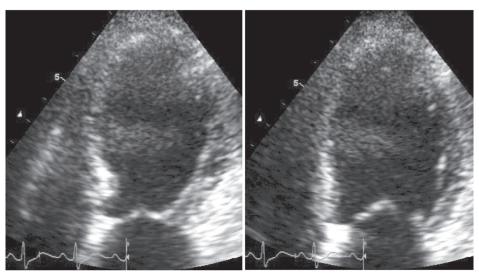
Echocardiograms show dilated left ventricle, poor left ventricular systolic function.
